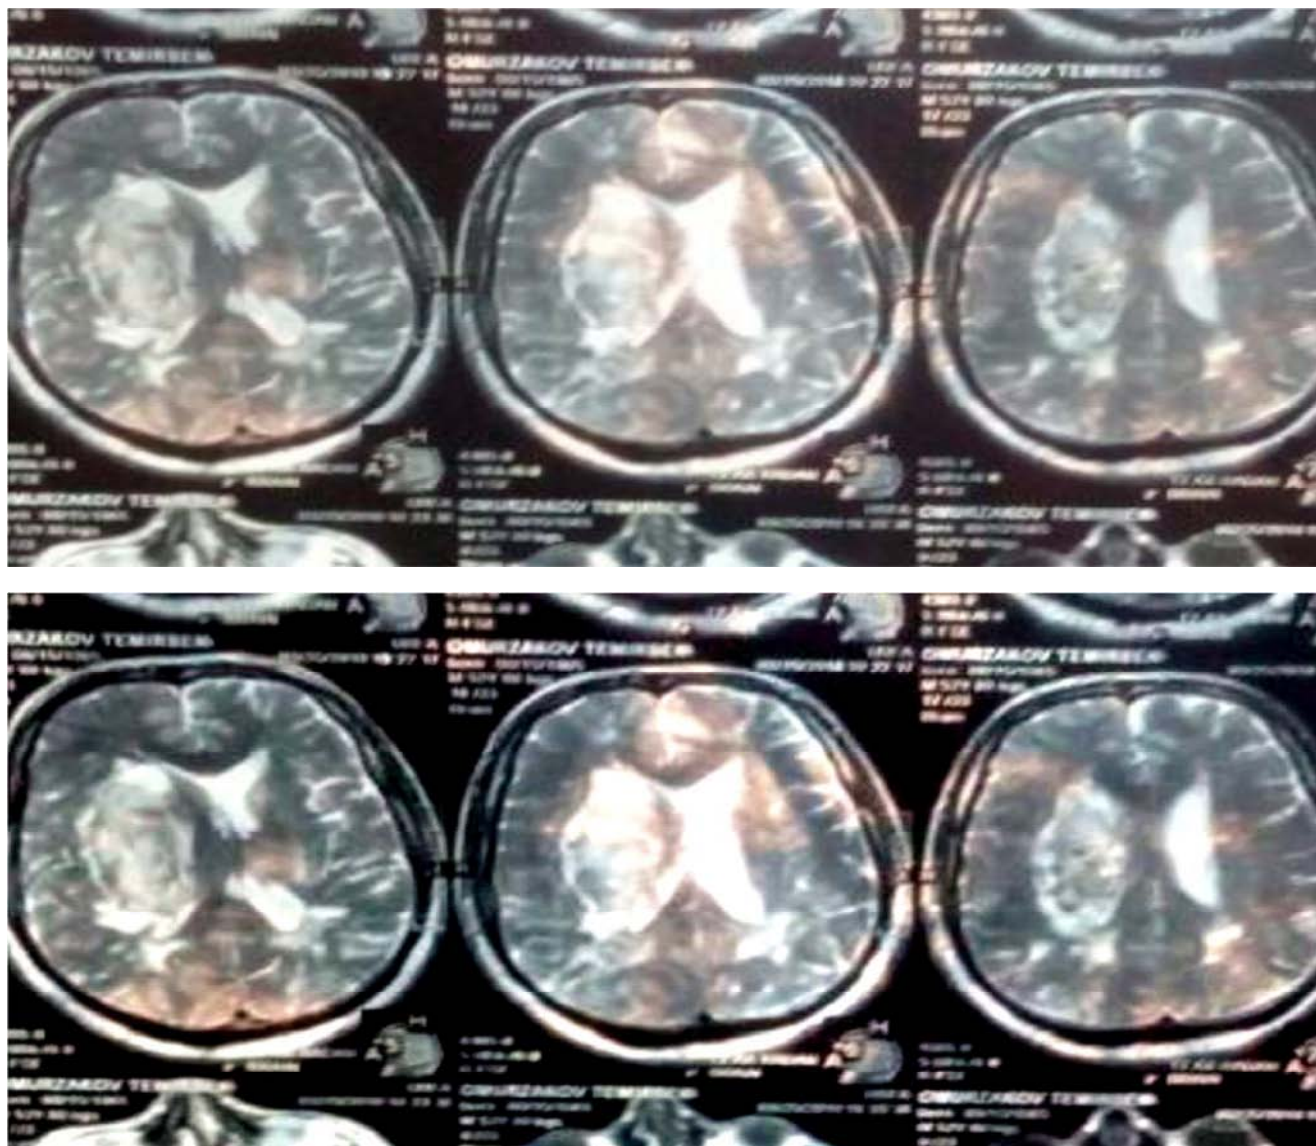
MRI-type brain scan - intracerebral hematoma.
